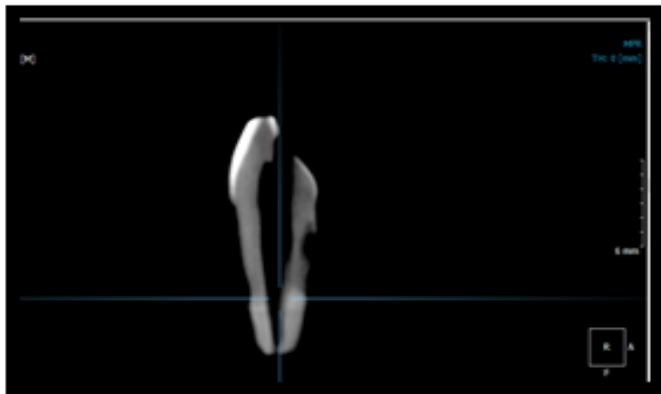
Figure a: Pre - obturation volumetric analysis in CBCT scan
